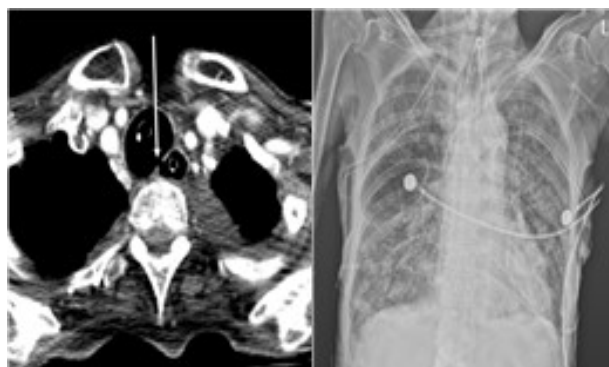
A preoperative computed tomography (A) and chest anterior-posterior image (B).
